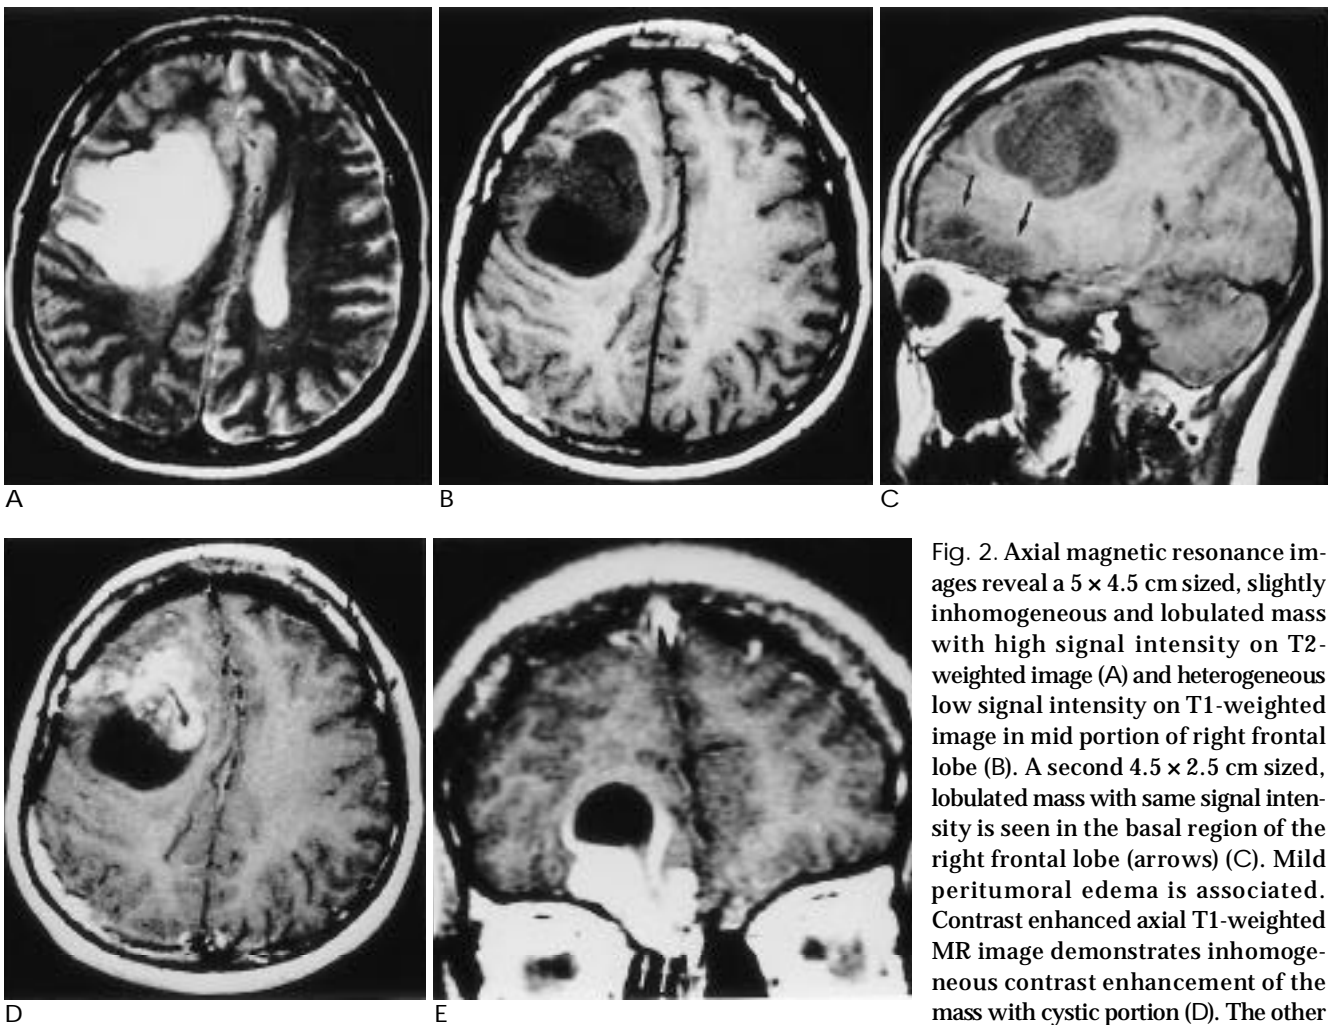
Axial magnetic resonance images reveal a 5 x 4.5 cm sized, slightly inhomogeneous and lobulated mass with high signal intensity on T2-weighted image (A) and heterogeneous low signal intensity on T1-weighted image in mid portion of right frontal lobe (B). A second 4.5 x 2.5 cm sized, lobulated mass with same signal intensity is seen in the basal region of the right frontal lobe (arrows) (C). Mild peritumoral edema is associated. Contrast enhanced axial T1-weighted MR image demonstrates inhomogeneous contrast enhancement of the mass with cystic portion (D). The other smaller mass shows extension to the right ethmoid sinus (arrows) (E).
